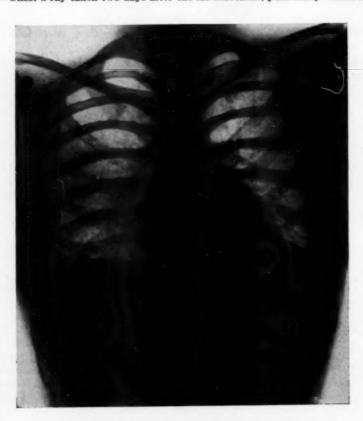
Chest x-ray immediately after recovery.
